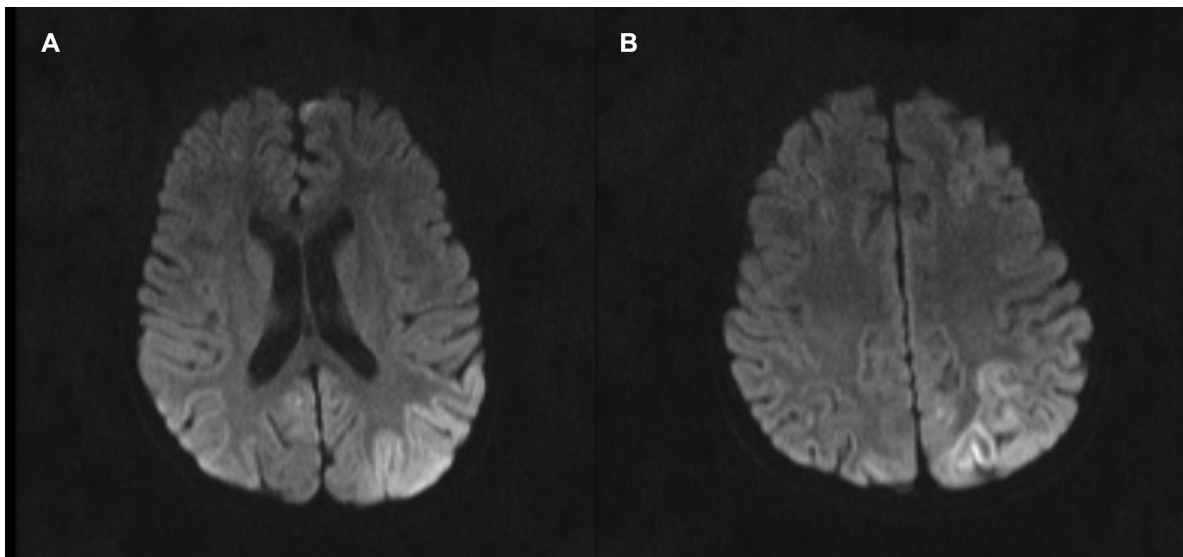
(A and B) Two sections of magnetic resonance imaging (MRI) brain – hyperintensities along the cortices of the left parieto-temporo-occipital lobe, left dorsomedial thalamus, and right frontal and occipital lobes, showing diffusion restriction.
